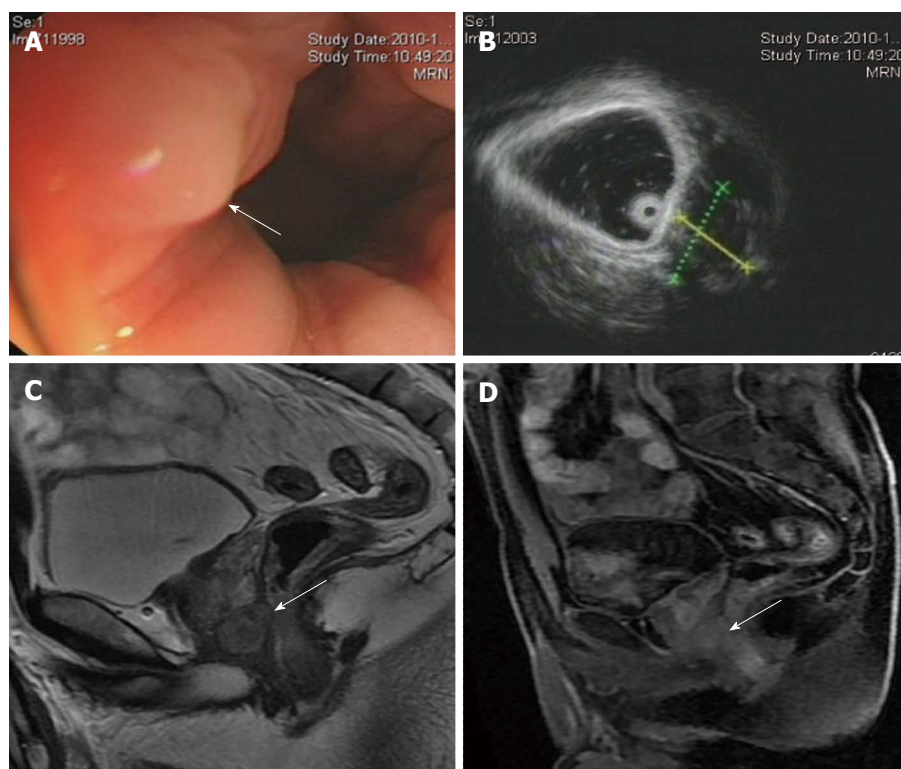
A 40-year-old man with a rectal gastrointestinal stromal tumor. A: Colonoscopy shows a mass protruding from the rectal wall with intact overlying mucosa (arrow); B: Endoscopic ultrasonography shows a well-defined hypoechoic mass located along the right anterior aspect of the rectal wall; C: Sagittal T2-weighted magnetic resonance imaging shows an oval, homogenous, hyperintense mass with a sharp margin bordering the anterior rectal wall. A small area of anatomical continuity between the tumor and the anterior rectal wall is observed (arrow); D: Postcontrast T1-weighted image shows a slightly homogeneously enhancing mass (arrow).
